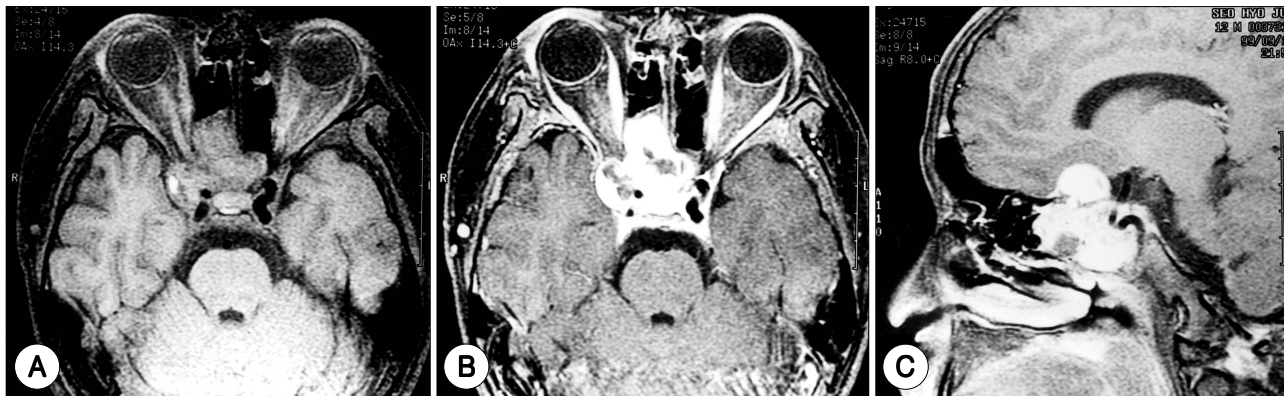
Preoperative magnetic resonance image. A : Axial T1 weighted magnetic resonance image showing isointense to slightly hypointense signal in sellar, parasellar, sphenoid sinus. B, C : Contrast axial and sagittal magnetic resonance images showing strongly enhancing large mass.
